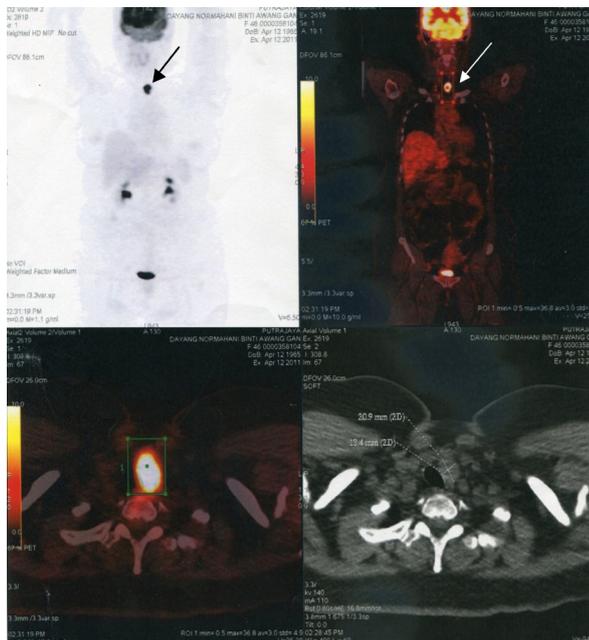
¹⁸F-FDG-PET/CT showed focus of FDG hypermetabolism at left thyroid bed (arrow), which was diagnosed as FDG avid local recurrence.
